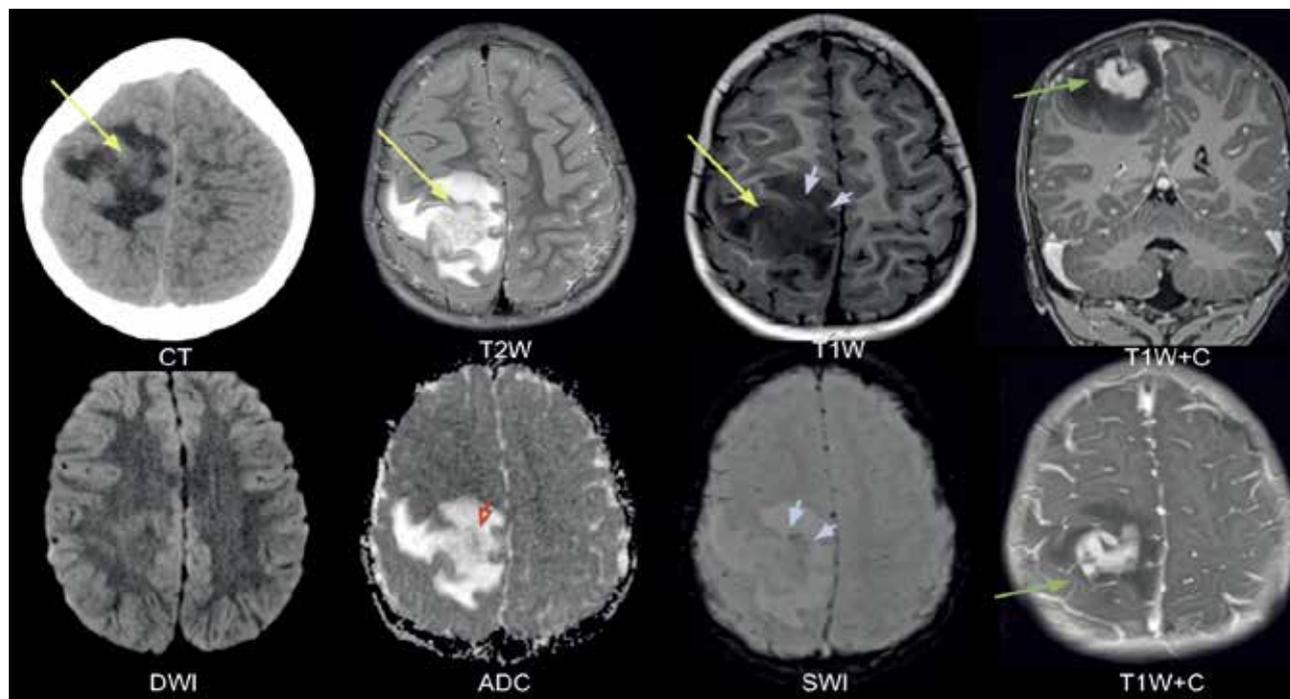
Non-contrast computed tomography (CT) and contrast-enhanced magnetic resonance imaging examinations of the brain. A solitary irregular intra-axial mass is seen at the right parietal lobe which is hyperdense on CT, isointense to grey matter on T1- and T2-weighted images (yellow arrows). Faint peripheral rim of susceptibility artefact is seen which is correspondingly T1-weighted hyperintense (short blue arrows). Focal central areas of restricted diffusion are seen as evident by low apparent diffusion coefficient value (open red arrow). Marked vivid contrast enhancement is demonstrated (green arrows).
